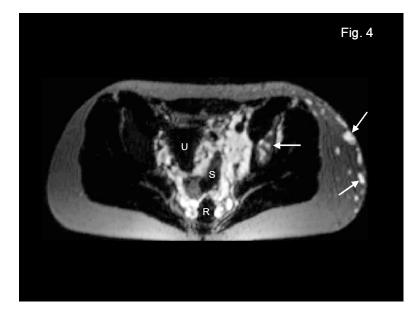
Axial heavily T2-weighted 3D-TSE source image depicts multiple lymphangiomatous changes with a high signal intensity in the pelvic region surrounding the uterus (u), sigmoid colon (s) and rectum (r), applying to the clinically observed anal lymphorrhea. Furthermore, lymphangiomatous changes are observed in the subcutaneous tissue and os ileum on the left side (arrows).
